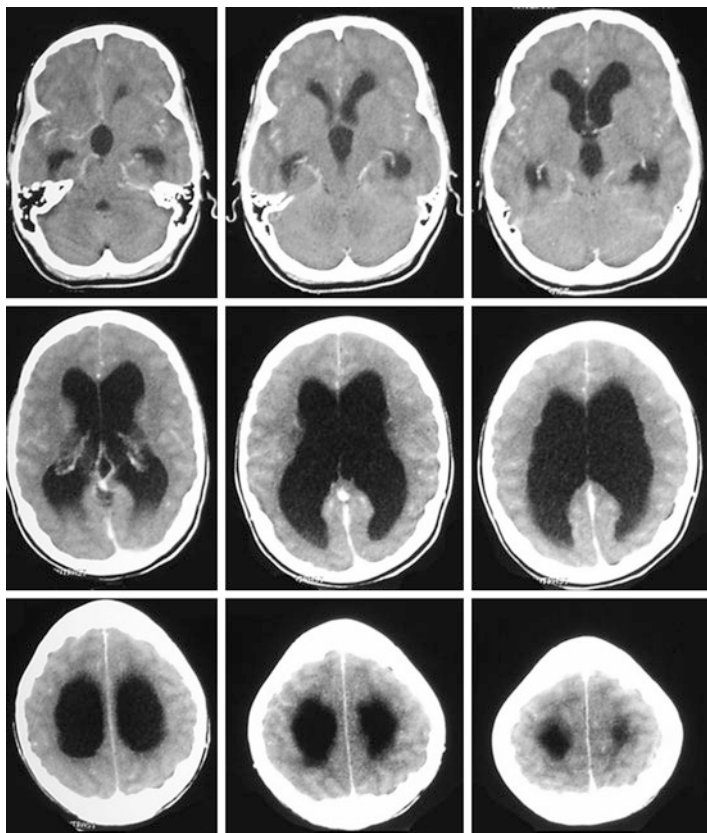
Non-contrast brain CT scan of a 22 year old male with 3 weeks history of headaches and blurring of vision. Note the gross dilatation of the lateral ventricles (*the frontal horn, the body, occipital horn and temporal horns*) and the third ventricle. The sulci are effaced (see text)
